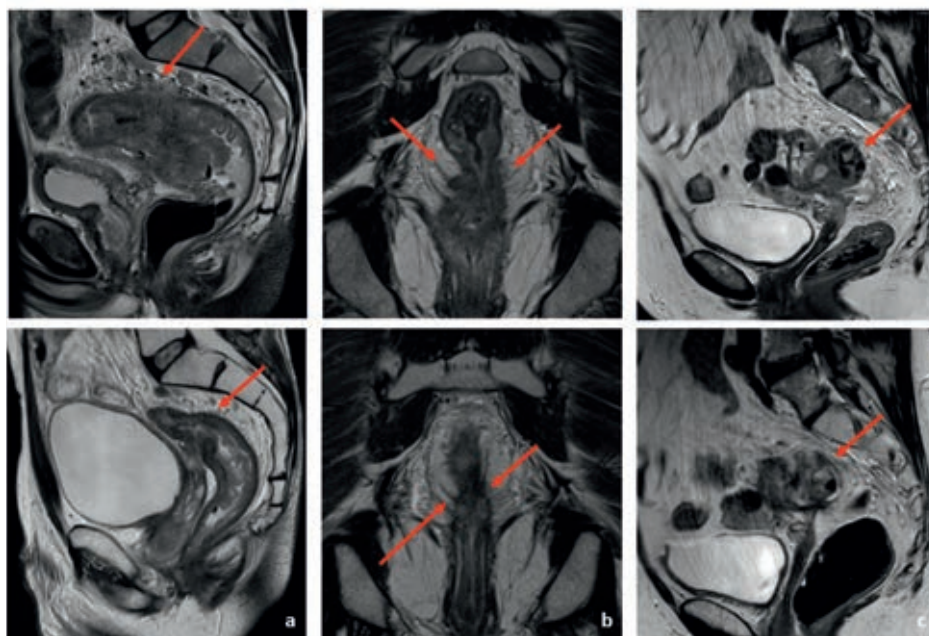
Magnetic resonance imaging (MRI) scans of patients with mrEMVI on primary imaging with complete response (mr-vTRG 1, *fig. 1a*), moderate response (mr-vTRG 3, *fig 1b*), and no response (mr-vTRG 5, *fig 1c*) on restaging MRI
